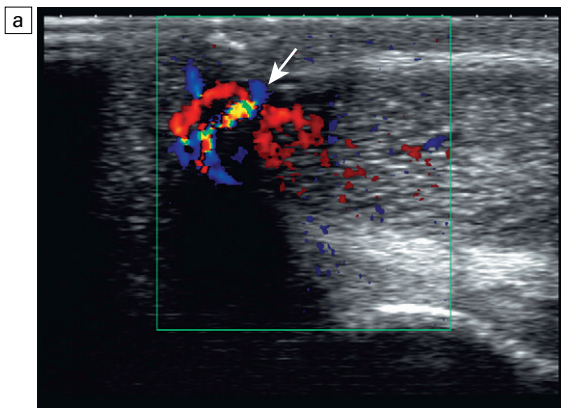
This patient sustained a penile injury while riding a bull 15 days prior to admission. The patient presented with a persistent painless erection. (a) Longitudinal colour Doppler image of the mid-penis. An area of colour flow aliasing within the left corpus cavernosa is the focus of the arterial lacunar fistula (arrow). (b) Corresponding spectral Doppler tracings. There is marked turbulent flow at the site as would be expected with an arterial–lacunar fistula. (c) Pre-embolisation arteriography. An early blush (arrows) corresponds to the site of the fistula. This was subsequently successfully embolised. This case is courtesy of Dr Vikram Dogra, Case Western Reserve University.
